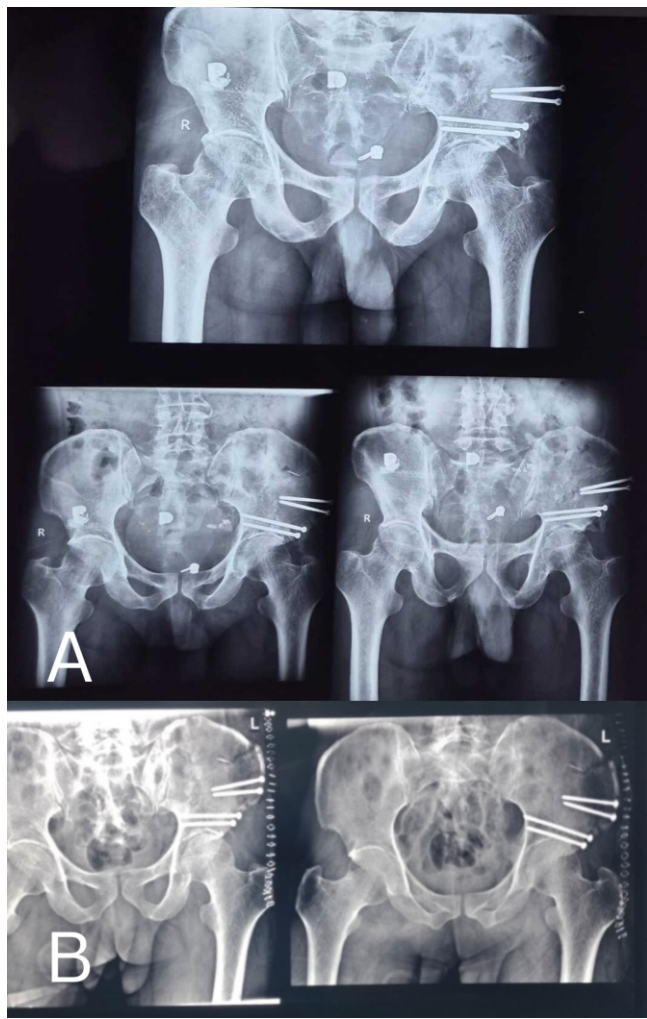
(A) Three months post-operative X-ray of the pelvis (B) Immediate post-operative X-ray of the pelvis.
